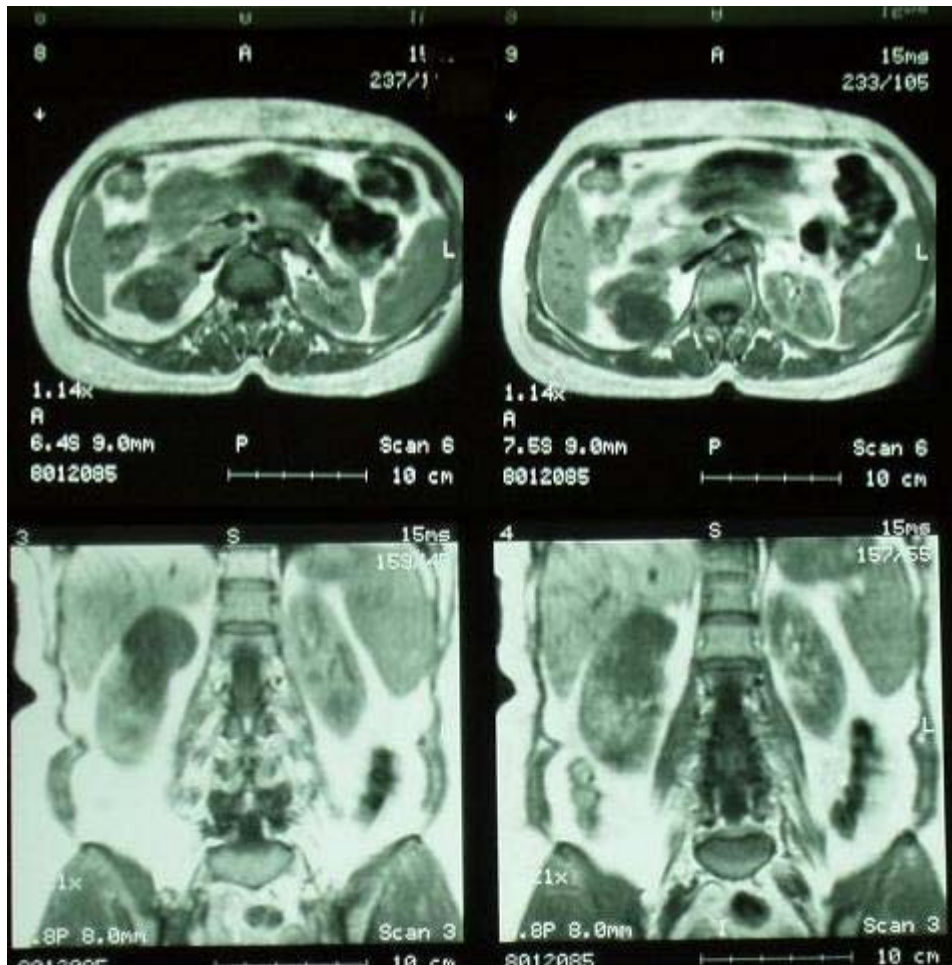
Axial and frontal views of MRI scans show an upper pole, posteriorly located right renal simple cyst, hyposignal on T1 and hypersignal on T2 images.
